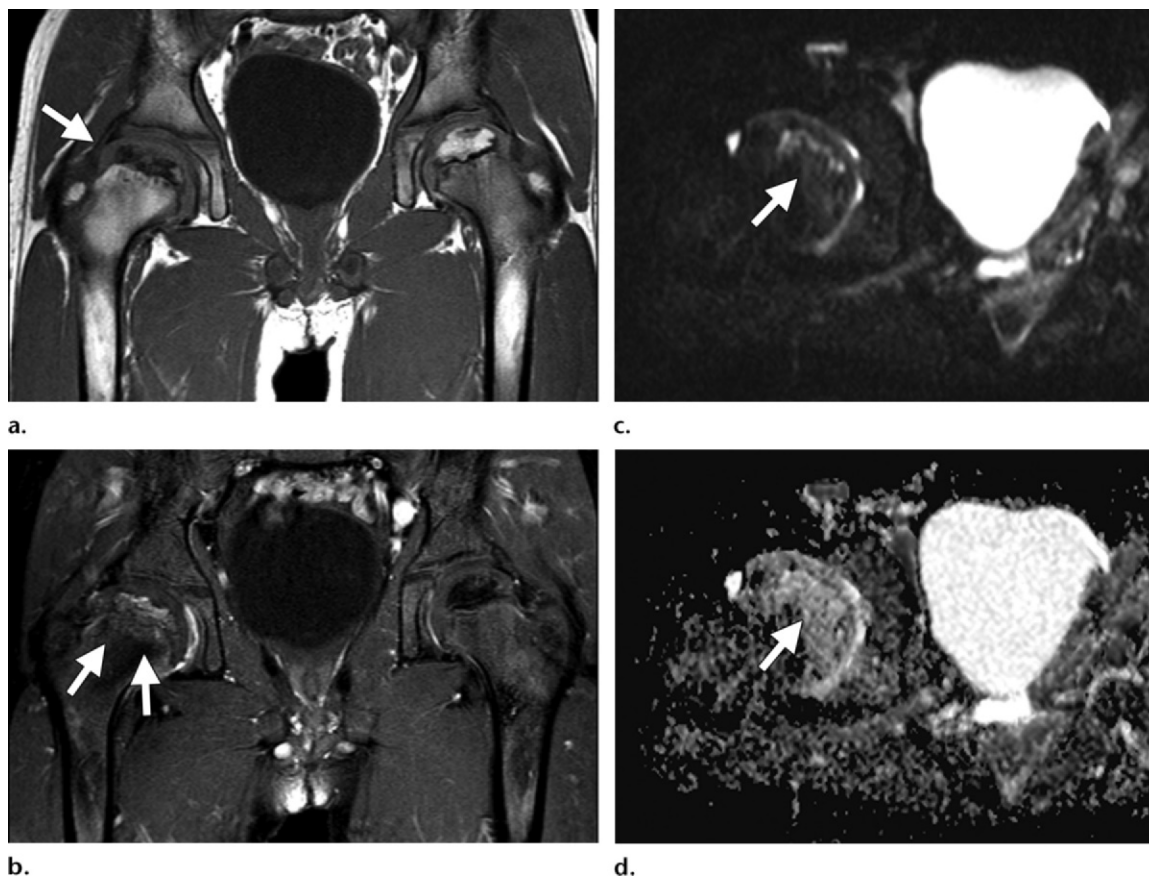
LCP disease in a 7-year-old boy with right hip pain. (a) Coronal T1-weighted MR image shows collapse of the right capital epiphysis, with central necrosis and lateral extrusion of the femoral head (arrow). Note the femoral notch on the left femoral head (a normal variant). (b) Coronal postcontrast T1-weighted MR image shows increased perfusion surrounding the region of necrosis (arrows). (c, d) Sagittal oblique diffusion-weighted (c) and ADC (d) images show increased diffusion in the anterior aspect of the proximal right femoral metaphysis (arrow).
